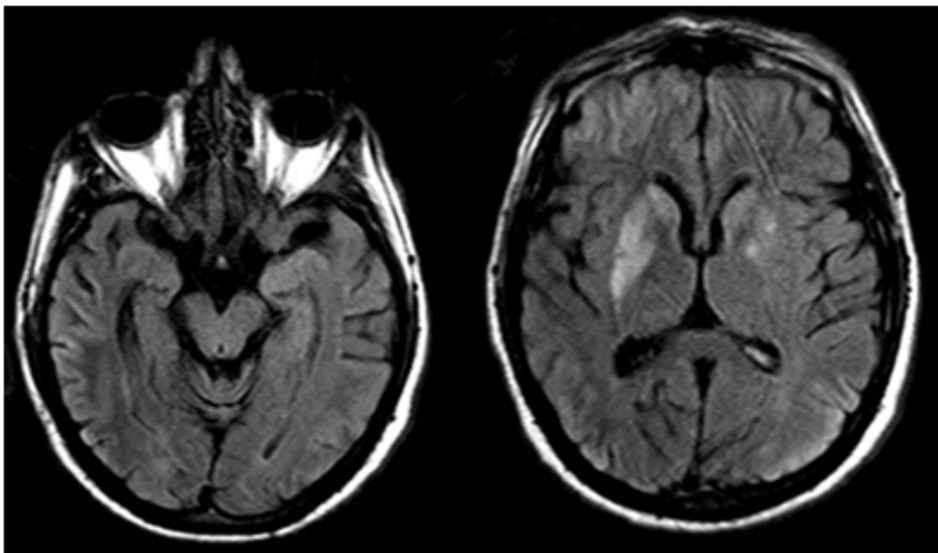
Increased signal intensity in the medial surface of the temporal lobe on the left hemisphere with increased volume of the corresponding region and increased signal intensity of the basal ganglia bilaterally and of the occipital cortex on axial Fluid-Attenuated Inversion Recovery (FLAIR) images.
